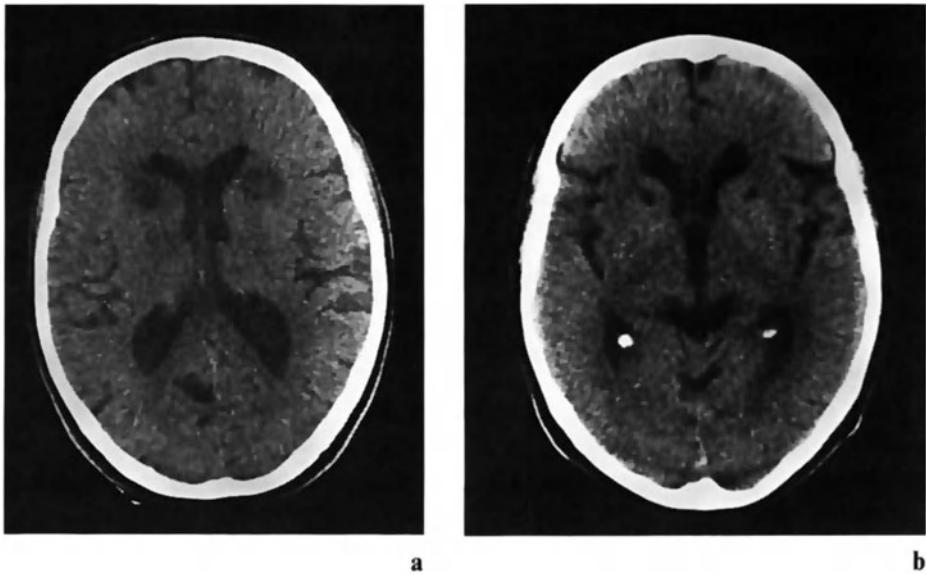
Internal capsule lesion after radiofrequency electrocoagulation visualized by CT-scan. (a) Early (one week after operation), (b) late (one year after operation)
